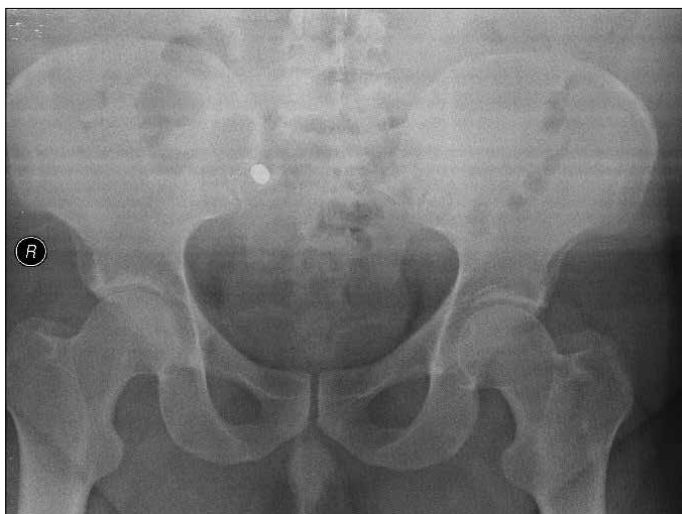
Radiographs of the localization of the bullet after 7 h
